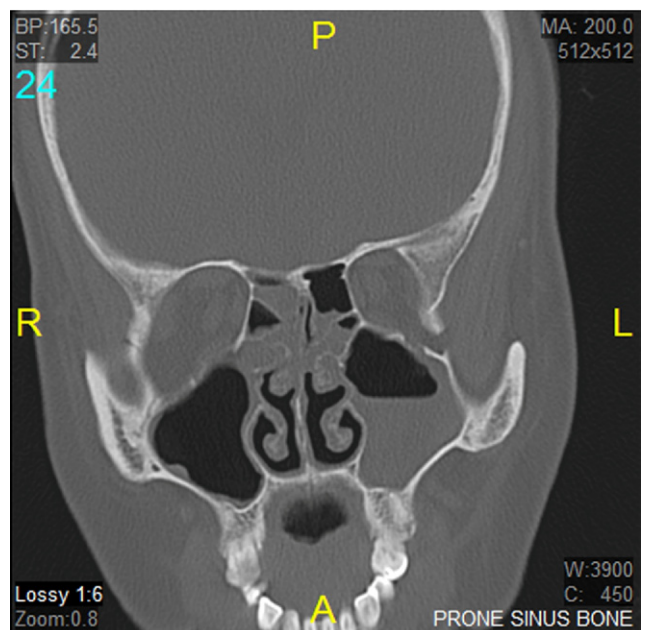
CT-Scan: Coronal image showing ethmoid sinus mucosal thickening and left maxillary sinus air-fluid level.
